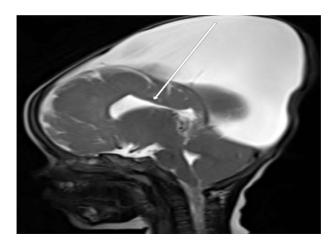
Sagittal T2-weighted image demonstrating the absence or hypoplasia of the posterior aspect of the corpus callosum (indicated by the white arrow).
